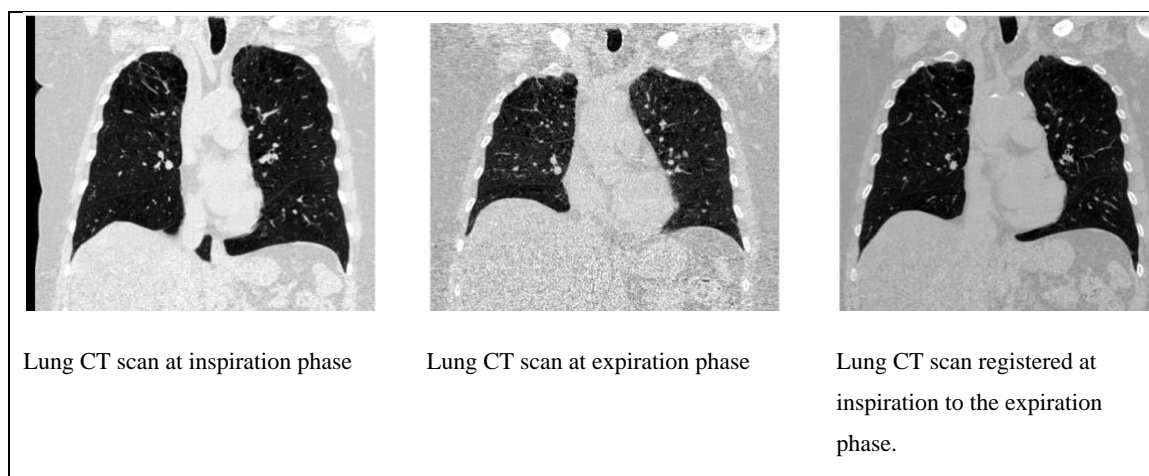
An example of a lung CT scan at inspiration, expiration, and the registered image at inspiration to expiration.
